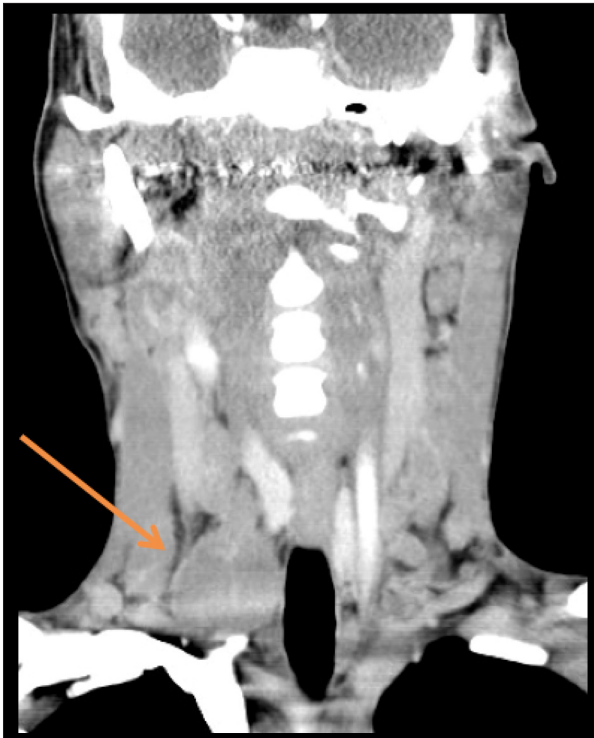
At presentation, contrast-enhanced CT scan of the neck, revealing bilateral cervical lymphadenopathy; the largest node was in the right supraclavicular region (arrow) with central low attenuation relative to periphery with enhancement.
